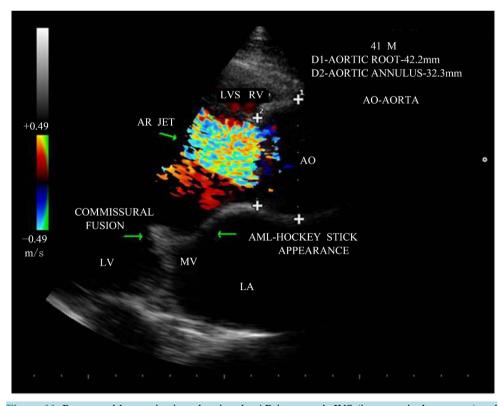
Parasternal long axis view showing the AR jet towards IVS (interventricular septum) and dilated aortic root—42.2 mm, aortic annulus—32.3 mm.
